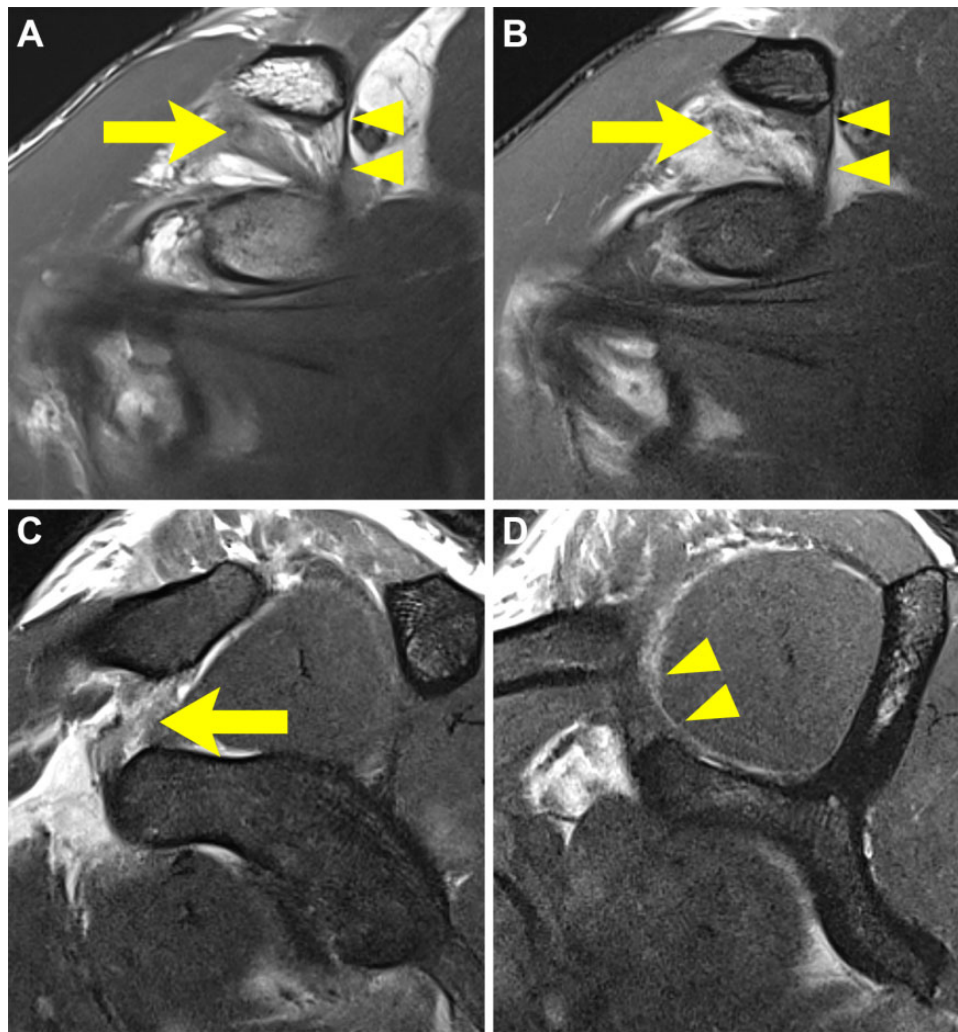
Grade 2 acromioclavicular injury: partial injury of coracoclavicular ligaments. (A) Coronal intermediate, (B) coronal T2-weighted fat suppressed, and (C, D) sagittal T2-weighted magnetic resonance imaging scans show acute tearing and disruption of the trapezoid ligament (arrows) and intact conoid ligament (arrowheads).
